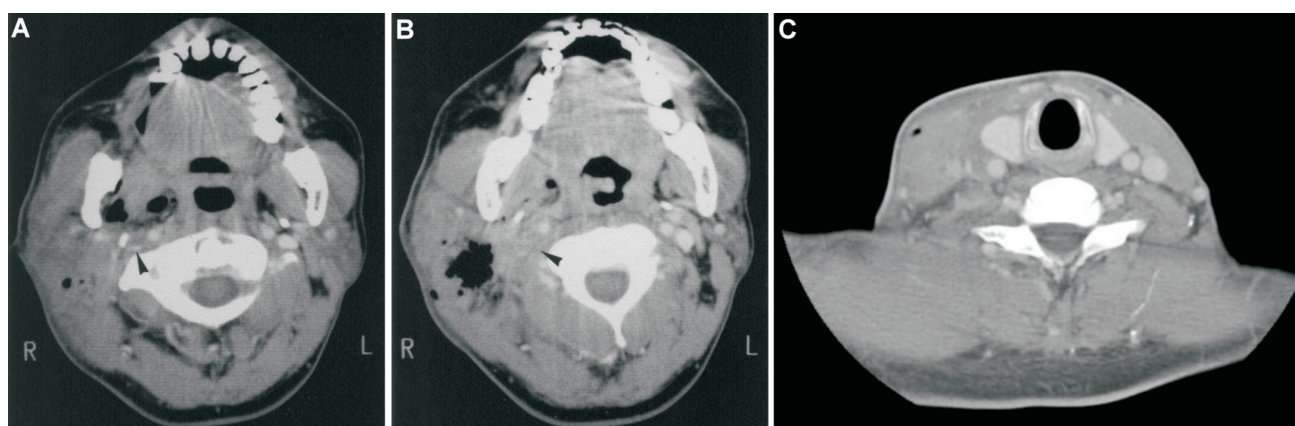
A series of contrast enhanced axial computed tomography (CT) of the neck: (A) At the level of the oropharynx, showing a gas-containing mass occupying the right-sided masticator and parotid space, spreading to adjacent prestyloid parapharyngeal and carotid space. Almost obliteration of the ipsilateral internal jugular vein (IJV) (arrowhead) due to the intraluminal thrombus is demonstrated. (B) On the consecutive caudal cut of image, the IJV (arrowhead) was seen totally occluded, and filled with a hypoattenuating intraluminal thrombus. (C) Tissue swelling of the right-sided lateral cervical space is still presented and IJV was recanalized, showing a narrowed, crescent shape lumen (arrowhead).
